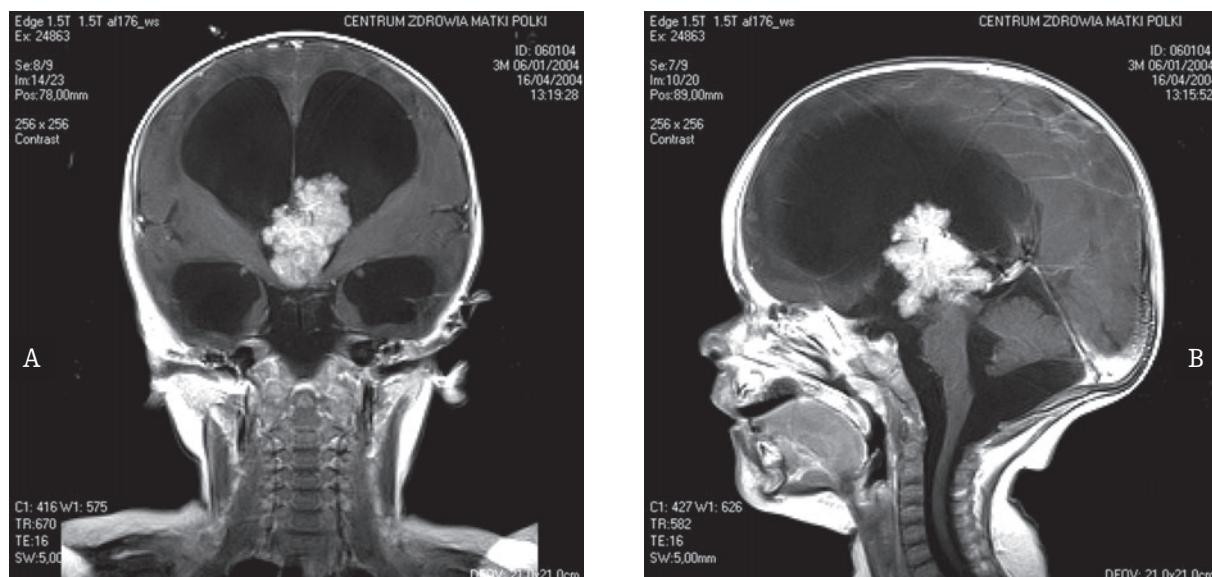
Postcontrast T1-weighted coronal (A) and axial (B) MR images demonstrate marked and lobulated mass (choroid plexus papilloma) within the third ventricle and obstructed Monroe's foramina of the lateral ventricles. Axial T2-weighted image shows severe hydrocephalus.
